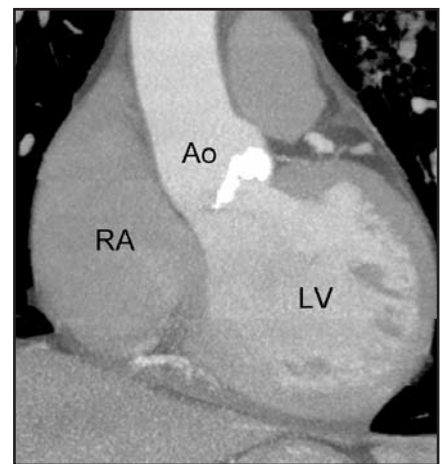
This cardiac CTA (coronal view) of the heart shows significant aortic valve calcification. (Ao = aorta; RA = right atrium; LV = left ventricle.)
